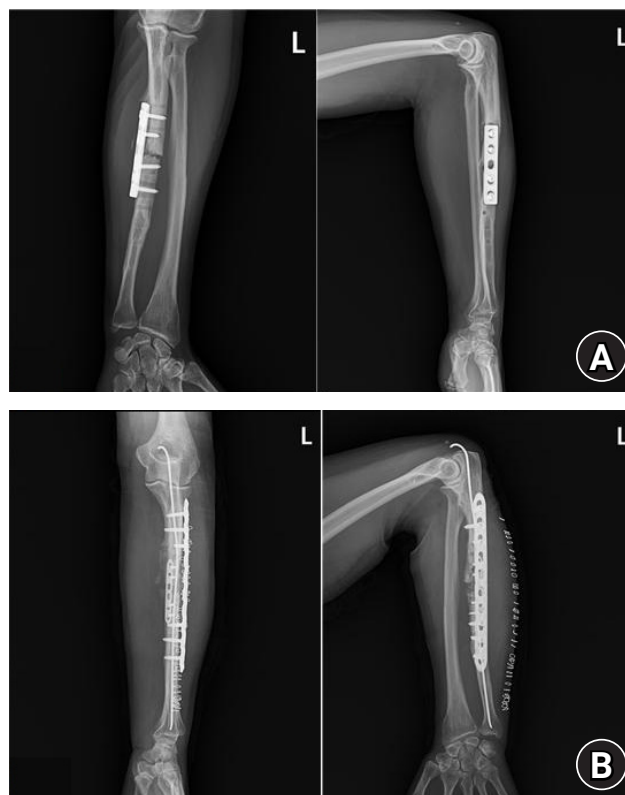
A 65-year-old female patient with established nonunion after prior ulnar fixation. (A) Preoperative radiographs. (B) Immediate postoperative radiographs after revision fixation using a nail-plate construct.
